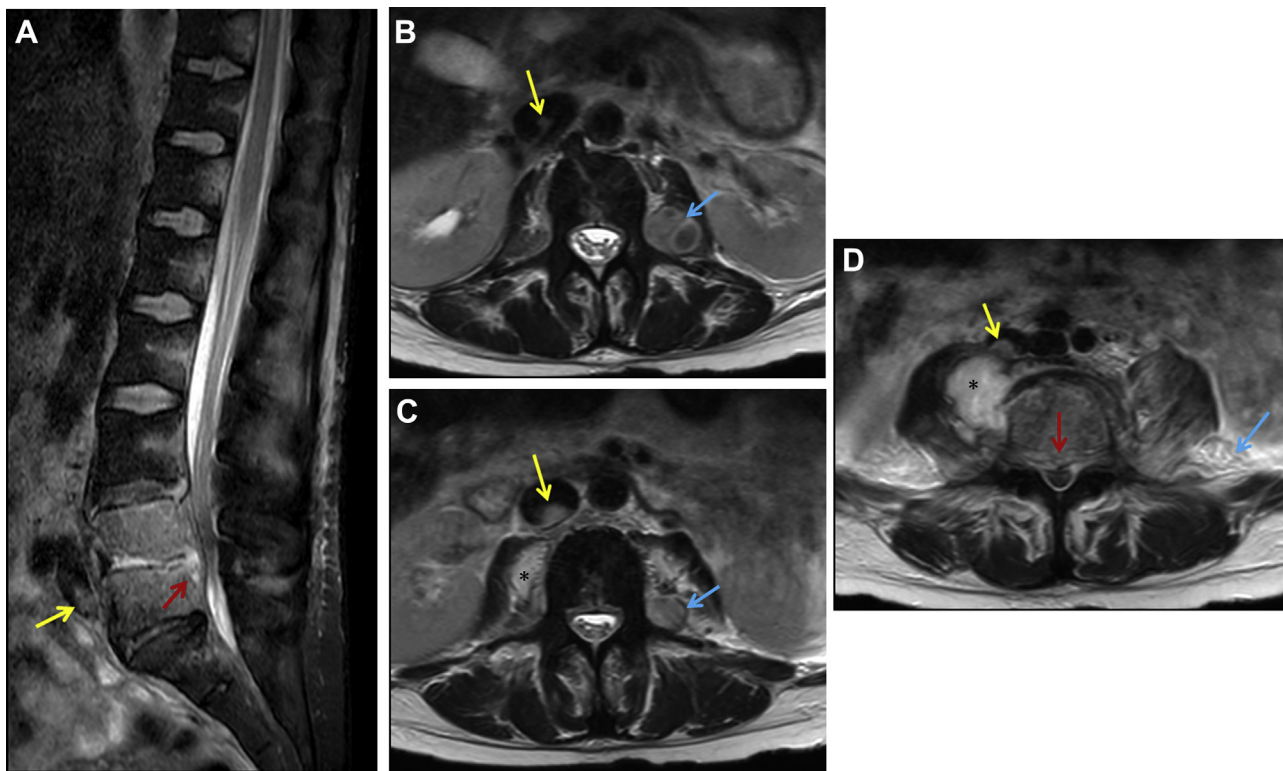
Sagittal T2 with fat saturation MR (A) and axial T2 MR (B-D) images from MR imaging of the lumbar spine demonstrate abnormal signal within the L4 and L5 vertebral bodies and L4-5 disc space with extension into the anterior epidural space (red arrows). Extensive paravertebral T2 hyperintense inflammatory change extending into the psoas muscles. T2 hyperintense collection is present within the right psoas muscle consistent with an intramuscular abscess (*) and similar signal collections within the paraspinal region reflecting either additional abscess collections or necrotic lymph nodes (blue arrows). Incidentally noted are T2 hyperintense filling defects within the right IVC and the bilateral iliac veins (yellow arrows).
